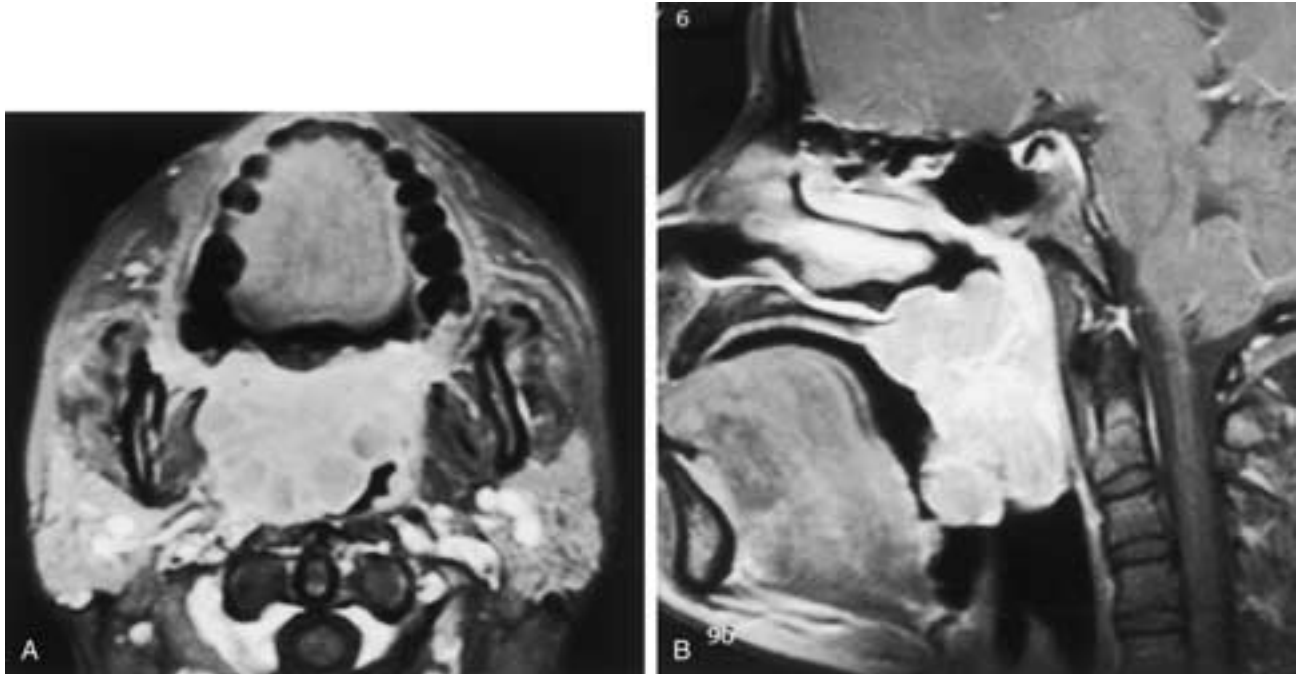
Mucoepidermoid carcinoma of the soft palate (low grade). Contrast-enhanced, fat-suppressed T1-weighted MR images in the (A) axial and (B) sagittal planes demonstrate a large, lobulated, overall benign-appearing lesion. Multiple nests of cells are present, rather than sheets of solid neoplastic cells. Note the significant airway compromise.
